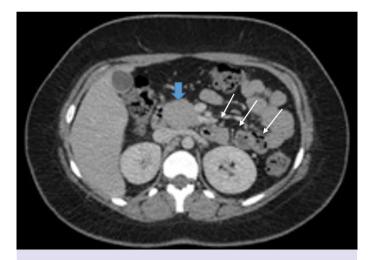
On the axial section, contrast-enhanced computed tomography scan images, head of pancreas could see (blue arrow) but the neck, body, and tail of the pancreas are not visualized and potential space is filled with intestinal loops (white arrows).
